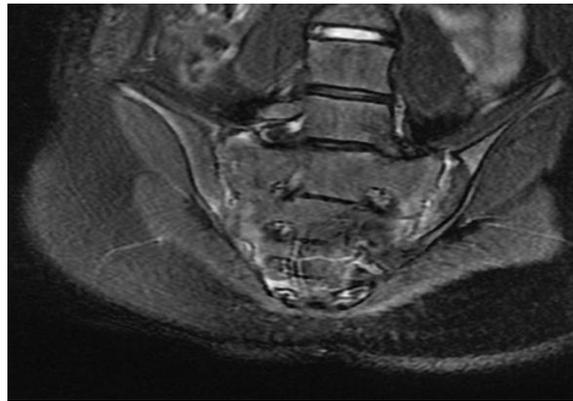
MRI of the bilateral sacroiliac joints.
